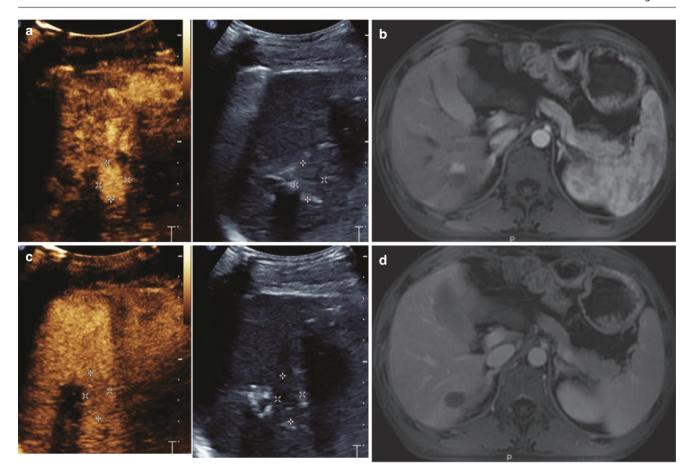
Recurrence of hepatocellular carcinoma (HCC). A 44-year-old man with liver cirrhosis and recurrence of HCC. The lesion on VI hepatic segment beside the primary lesion that had surgical excised 6 months before. The lesion could not be detected on B mode ultrasound
